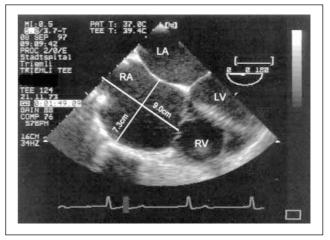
Transesophageal echocardiogram showing a grossly dilated right atrium and a moderately dilated left atrium without any active contraction
